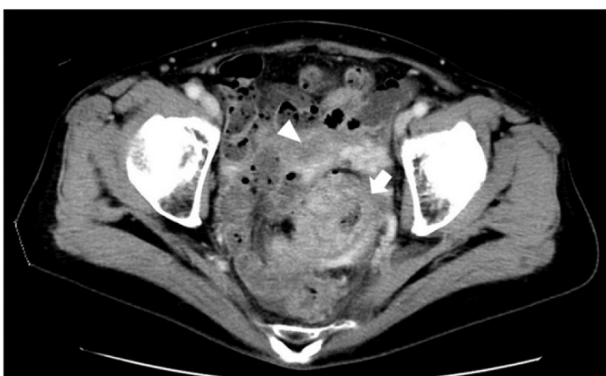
Computed tomography at the time of diagnosis. At diagnosis, computed tomography revealed a large tumor in the sigmoid colon complicated with diverticulitis (arrow), which extended into the pelvis and possibly invaded the uterus (arrowhead) and pelvic wall (T4bN1bM0).
